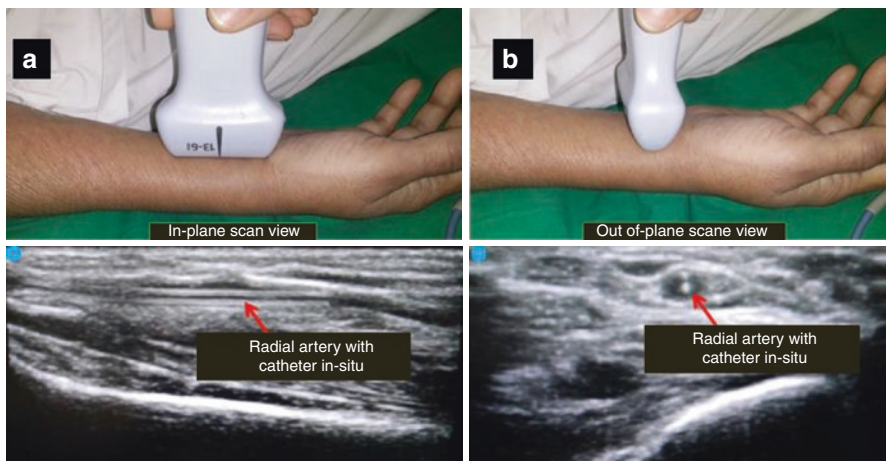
Ultrasound views of radial artery. a. In-plane scan view of radial artery is obtained when the long axis of probe is parallel to the long axis of the artery b. Out of plane scan view of radial artery is obtained when the long axis of the probe is kept perpendicular to the long axis of artery
